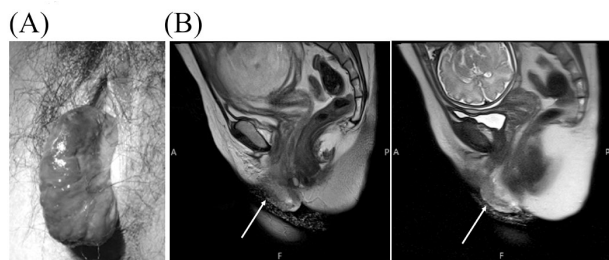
(A) Gross findings. The reddish vaginal mass protrudes from the vaginal introitus. (B) Imaging findings. MRI shows the thickened and enhanced vaginal mass (arrow) of the perineum (left: T2-weighted image, right: enhanced T2-weighted image).
